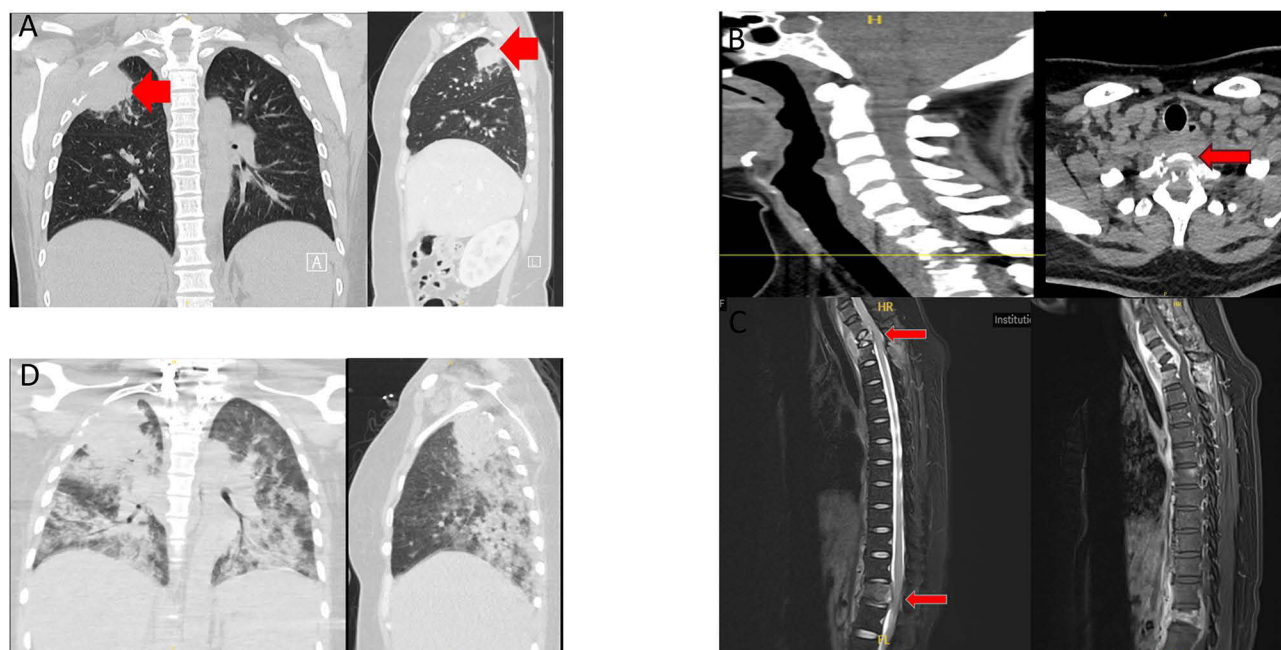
Imaging. (A) Preoperative chest CT: A poorly demarcated, irregular soft tissue mass (indicated by the red arrow) measuring approximately 4.9 cm × 3.8 cm × 3.7 cm was observed adjacent to the posterior segment of the right third rib in the thoracic cavity. The lesion exhibited indistinct boundaries with the adjacent right pleura, chest wall, and intercostal muscles, and protruded toward the apical segment of the right upper lobe. (2023-6-23). (B) Preoperative cervical spine CT: Osteolytic bone destruction was observed involving the vertebral bodies from C6 to Th2, predominantly affecting the Th1 vertebral body. These findings are suggestive of a pathological fracture of the Th1 vertebra (red arrow), with secondary spinal canal stenosis at the Th1 segment. (2023-7-3). (C) Preoperative whole spine MRI: Flattening of the Th1 and L1 vertebral bodies was observed (red arrows), suggestive of pathological fractures. Abnormal fluid-like signal intensities were noted in the Th1 and L1 vertebral bodies, their appendages, and surrounding soft tissues, protruding into the spinal canal and resulting in spinal cord compression at the levels of Th1 and L1. (2023-7-3). (D) Postoperative lung CT: An irregular, patchy soft tissue density mass located at the posterior segment of the right third rib in the right thoracic cavity increased in size compared to the previous examination. Patchy and linear high-density shadows appeared in both lungs, indicating progression of pulmonary inflammation relative to the preoperative state. (2023-7-6).
